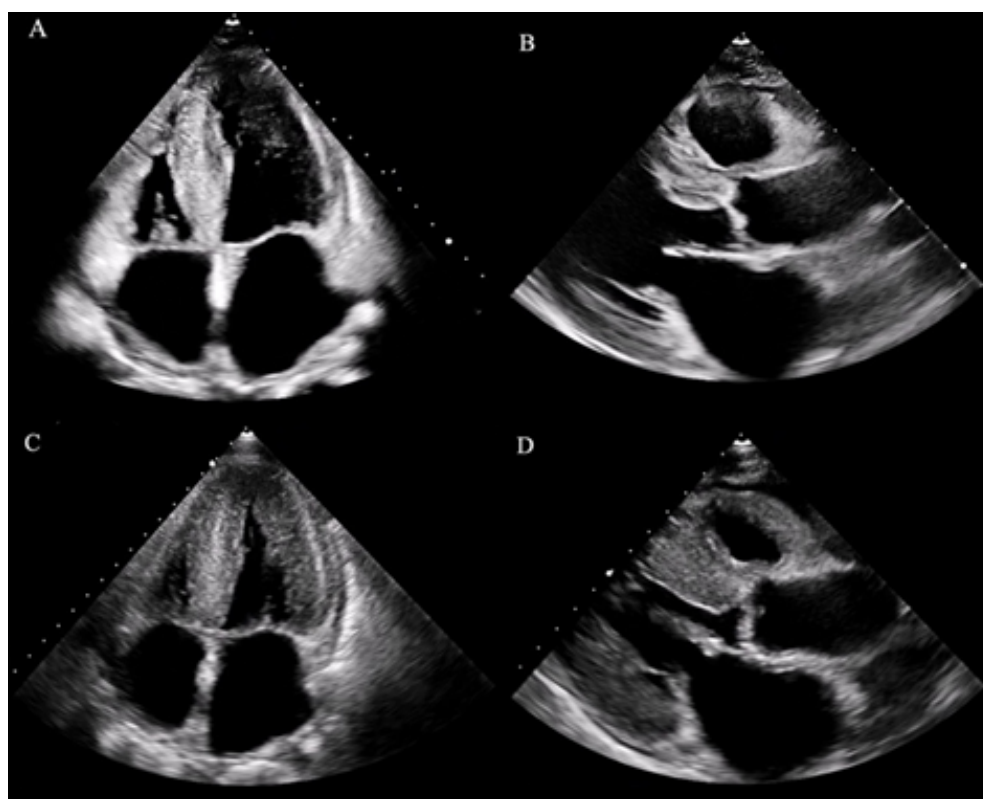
TTE demonstrating cardiac involvement in AL amyloidosis. TTE in both (A) apical four-chamber and (B) parasternal long-axis windows showing an increase in both left and right ventricular wall thickness. Repeat TTE after 9 months in both (C) apical four-chamber and (D) parasternal long-axis windows demonstrating worsening ventricular wall thickness. TTE: transthoracic echocardiography.
